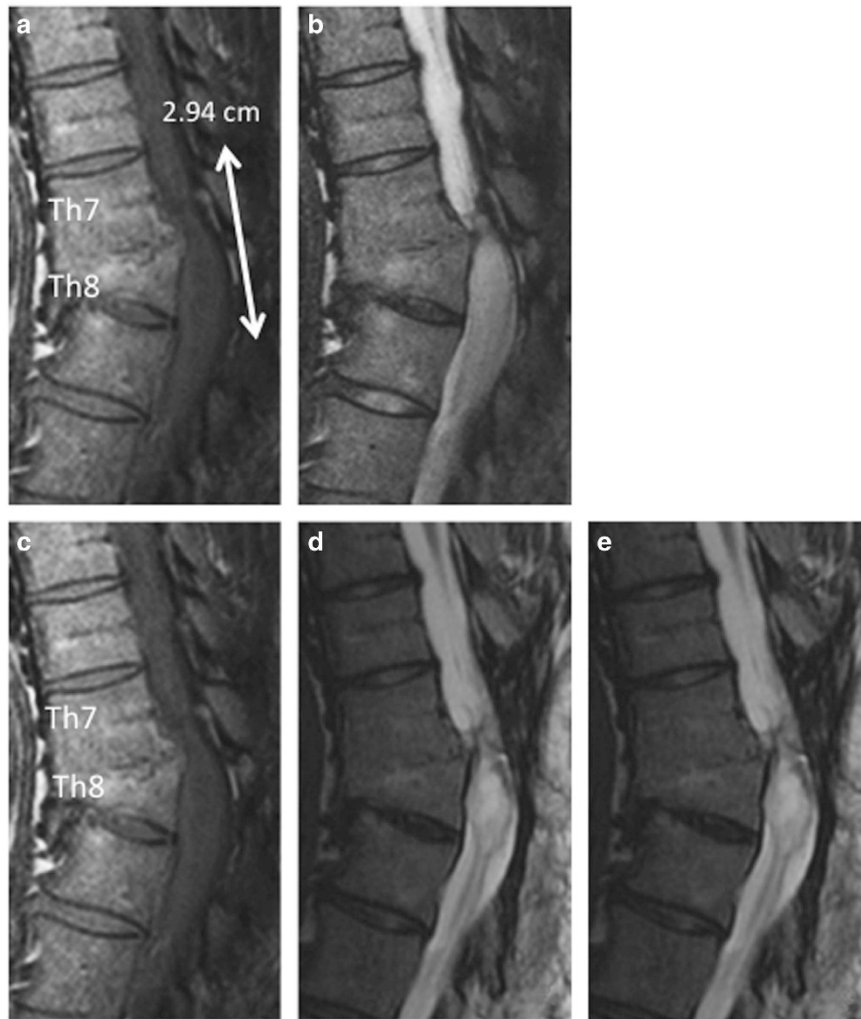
Magnetic resonance imaging (MRI). (a) T1-weighted sagittal image before transplantation shows atrophic change of the thoracic spinal cord. (b) T2-weighted sagittal image before transplantation shows an intramedullary high-intensity area. MRI at 48 weeks after transplantation shows fairly complete filling of cavities with heterogeneous intensity on T1- (c) and T2-weighted (d) images. (e) Gadolinium-enhanced images also show heterogeneous enhancement of the grafts. No evidence of neoplastic tissue overgrowth was observed during the initial follow-up period.
